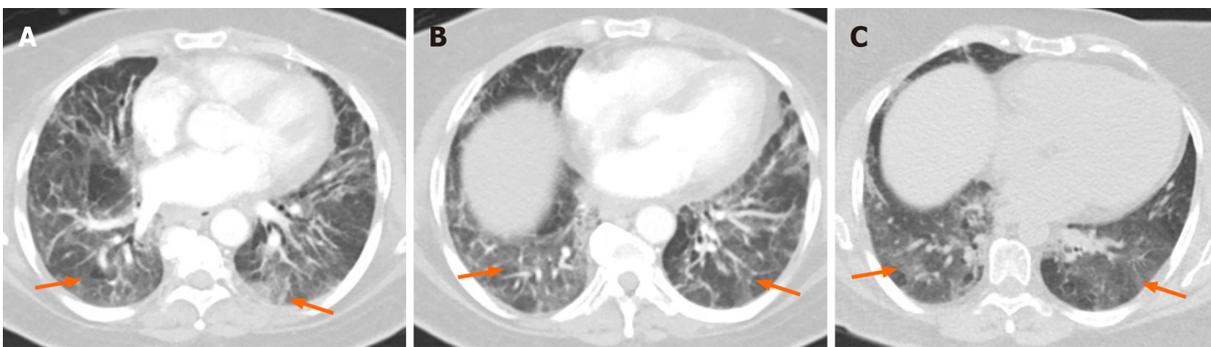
Another coronavirus disease 2019 infected 57 year old patient shows patchy ground glass opacities in both lower lobes without crazy-paving pattern (orange arrows) in postcontrast axial computed tomography chest in lung windows (A-C).
